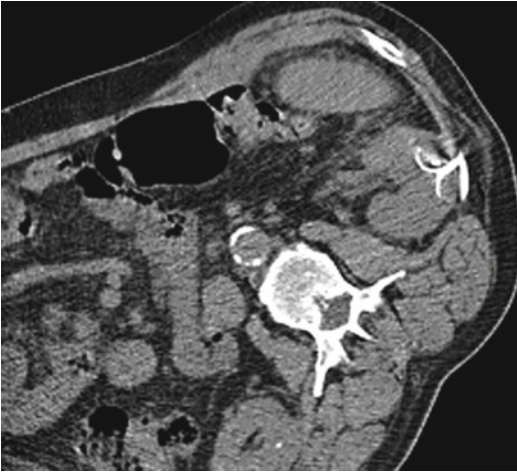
Lateral approach to a recurrent renal cell carcinoma located in the contralateral left kidney 37 months after right-sided nephrectomy for renal cell carcinoma. Peri-interventional nonenhanced CT demonstrates an RF probe within the tumor
